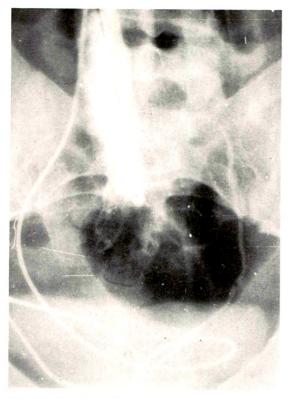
Case iv. Retrograde examination reveals blind end of left ureter at level of L-4 (artefact in mid-portion of roentgenogram).
